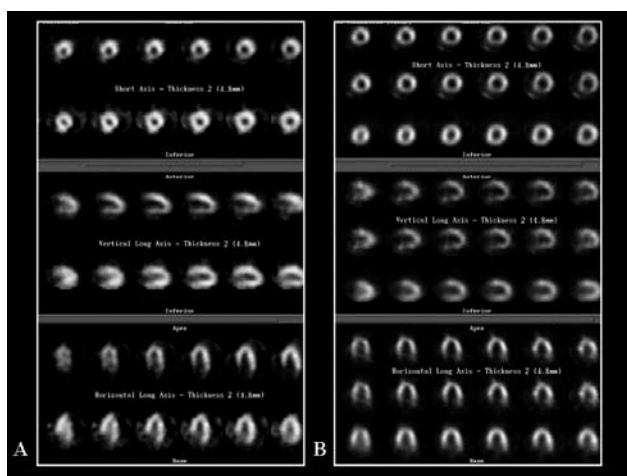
A. SPECT myocardial perfusion scan: Stress study (upper row images): Decreased sestamibi-Tc99m uptake is noted in the inferior myocardial wall. The same projection after placing the patient in prone position (lower row images): normal uptake in all myocardial walls. Inferior wall defect was due to attenuation artifact. B. SPECT myocardial perfusion scan: Stress study (upper row images): Decreased sestamibi-Tc99m uptake is noted in the inferior myocardial wall. The same projection after placing the patient in prone position (middle row images): no change in RP distribution in myocardial walls. Rest study (lower row images): increased sestamibi-Tc99m uptake in the inferior wall denotes ischemia.
